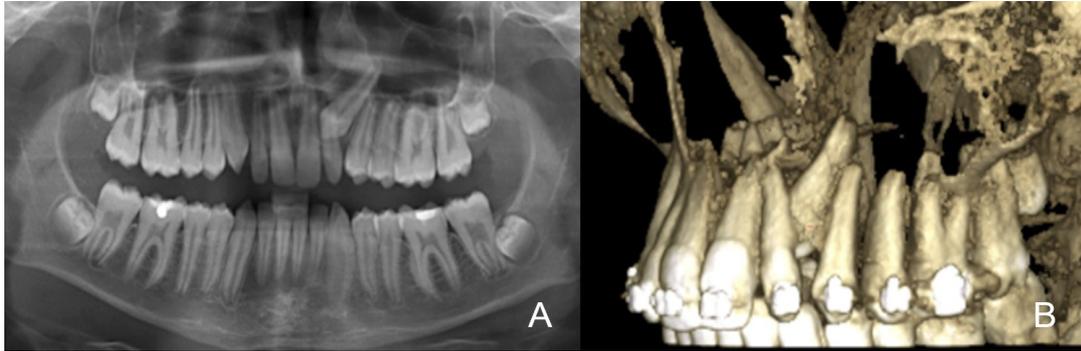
Adjacent peg-shaped PLI to IPMC: (A) on DPR image and (B) on 3D-reconstructed image of CBCT.
